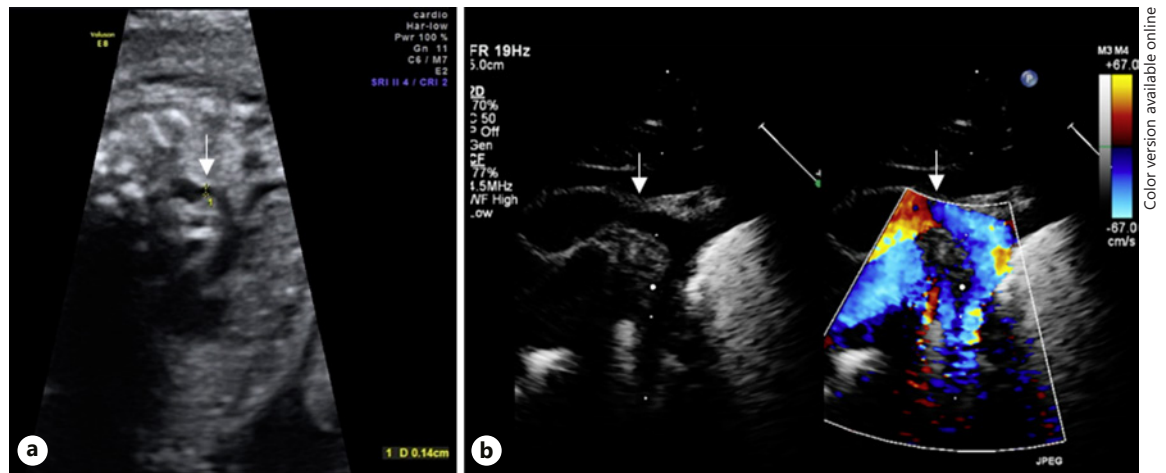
Ultrasound image of case 2 at 28 weeks' gestation (a) and after birth (b). Arrows indicate the coarcted segment.
